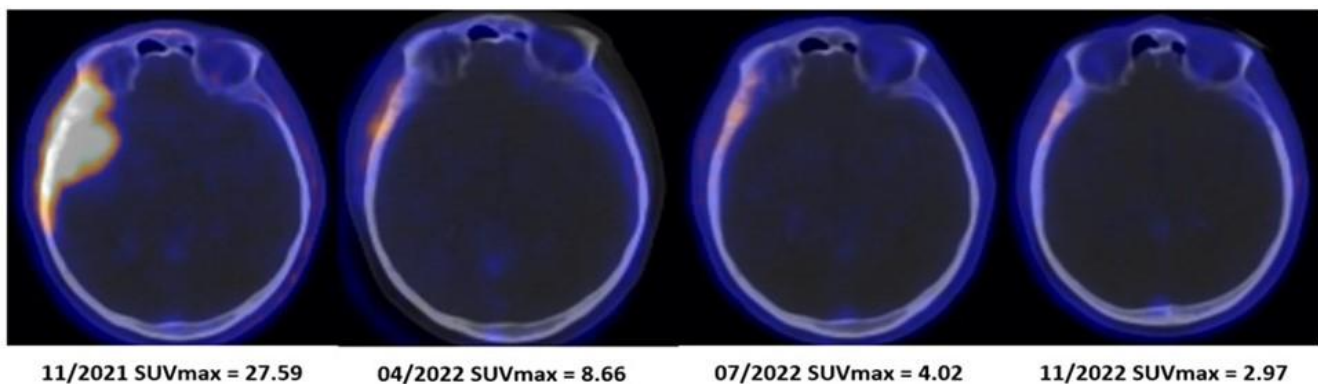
PET PSMA and response assessment: axial fusion images show progressive decrease of the SUVmax and of the skull lesion extension: A) Baseline study November / 2021 SUVmax = 27.59; B) April / 2022 SUVmax = 8.66; C) July / 2022 SUVmax = 4.02 and D) November / 2022 SUVmax = 2.97.
